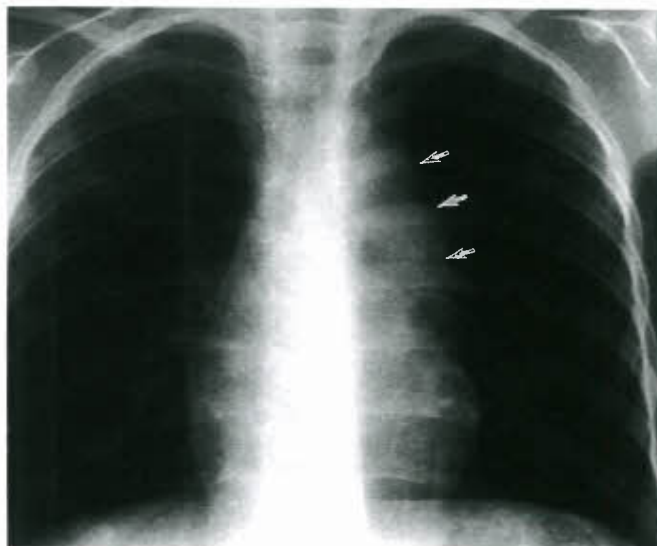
Chest radiography in congenitally corrected transposition of the great arteries. No intracardiac abnormalities. Note levopositioned aorta (arrows).
